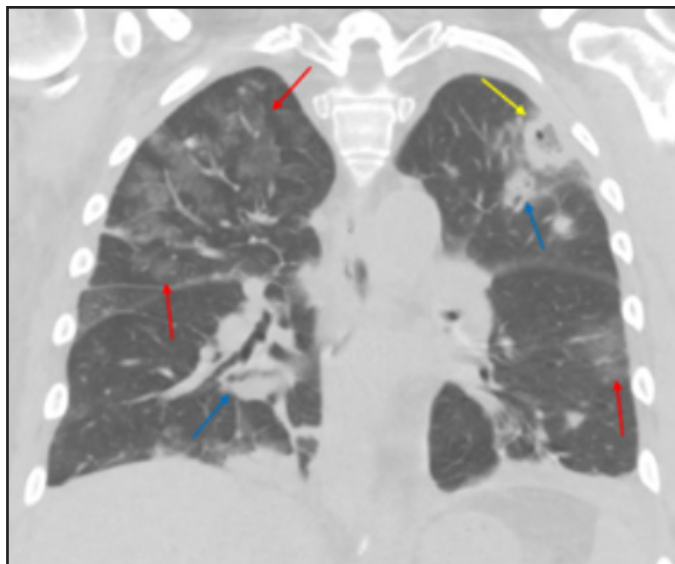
Multifocal MSSA pneumonia. Coronal noncontrast CT demonstrating thick-walled left upper lobe abscess (yellow arrow), multilobar consolidations (blue arrows), and ground-glass opacities (red arrows).
